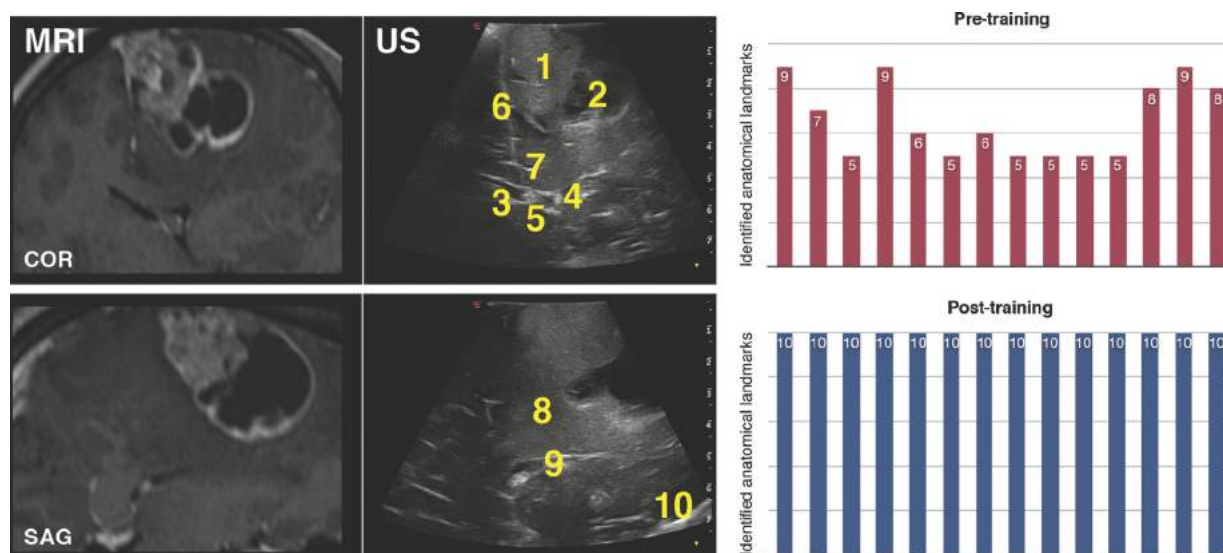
Fourteen European neurosurgery residents were first asked to identify 10 anatomical features using the developed software and visualizing US images only-scans. Each trainee could recognize 5 to 9 structures out of 10 (top graph - pre-training) before rehearsing the case and practicing with paired MRI-US scans by means of the USim (right + left columns of the panel). After rehearsal all the residents precisely identified all 10 anatomical structures on US images (bottom graph - post-training). From [PPM<sup>+</sup>17]
